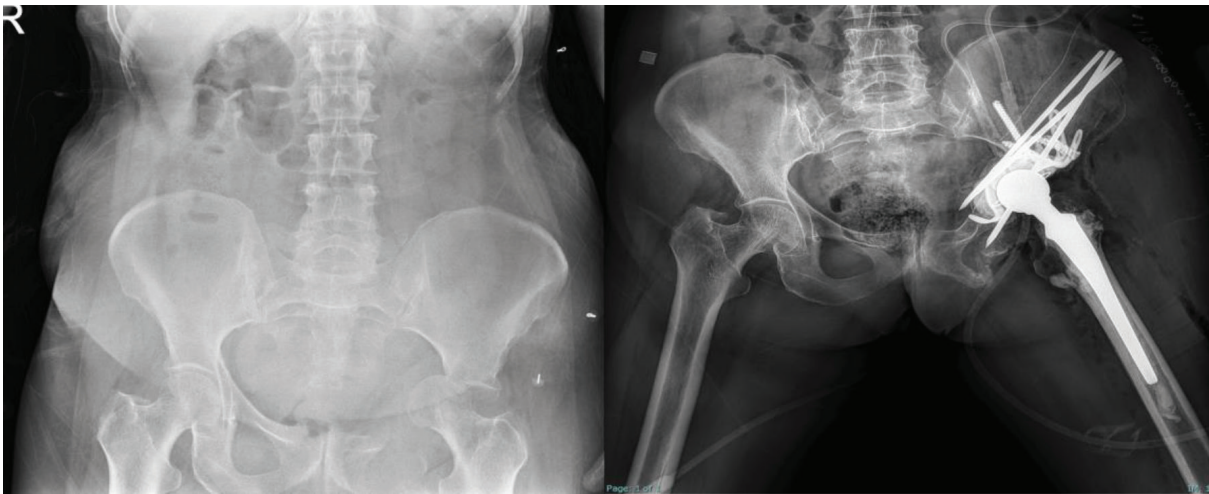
Preoperative and postoperative imaging-Harrington procedure. Preoperative (left) and postoperative (right) pelvic radiographs of a patient with primary bone lymphoma involving the iliac wing and acetabulum. Preoperative imaging shows bone destruction and loss of structural integrity in the left hemipelvis. The patient underwent Harrington reconstruction with total hip arthroplasty, Steinmann pins, plate fixation, and screws, providing structural stabilization and enabling functional restoration after oncologic treatment.
